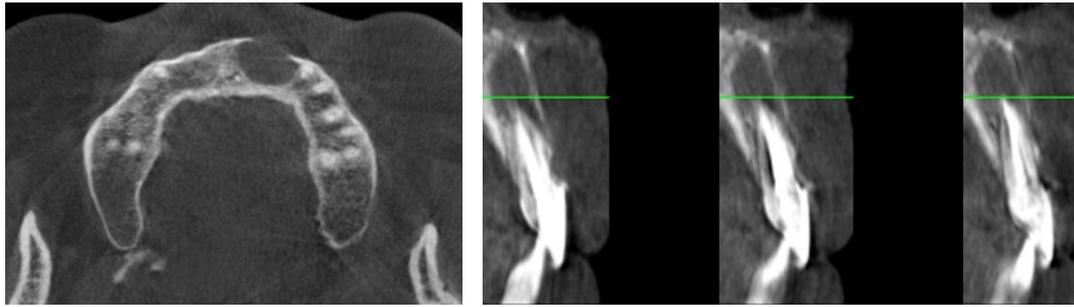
Axial and oblique coronal CBCT sections showing the periapical lesion with thinning and fenestration of the buccal cortical plate
